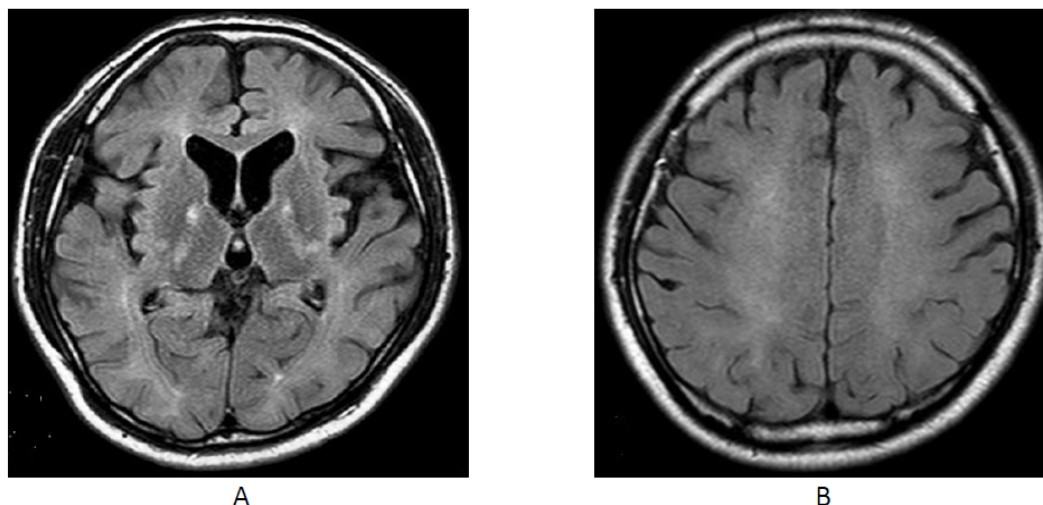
Transverse brain MRI findings 145 days after CO exposure. Hyperintense region in bilateral globus pallidus greatly reduced and mild cerebral atrophy was revealed (A). Moreover, it showed subsequent exacerbation in the white matter lesion especially in the frontal lobe (A) (B).
